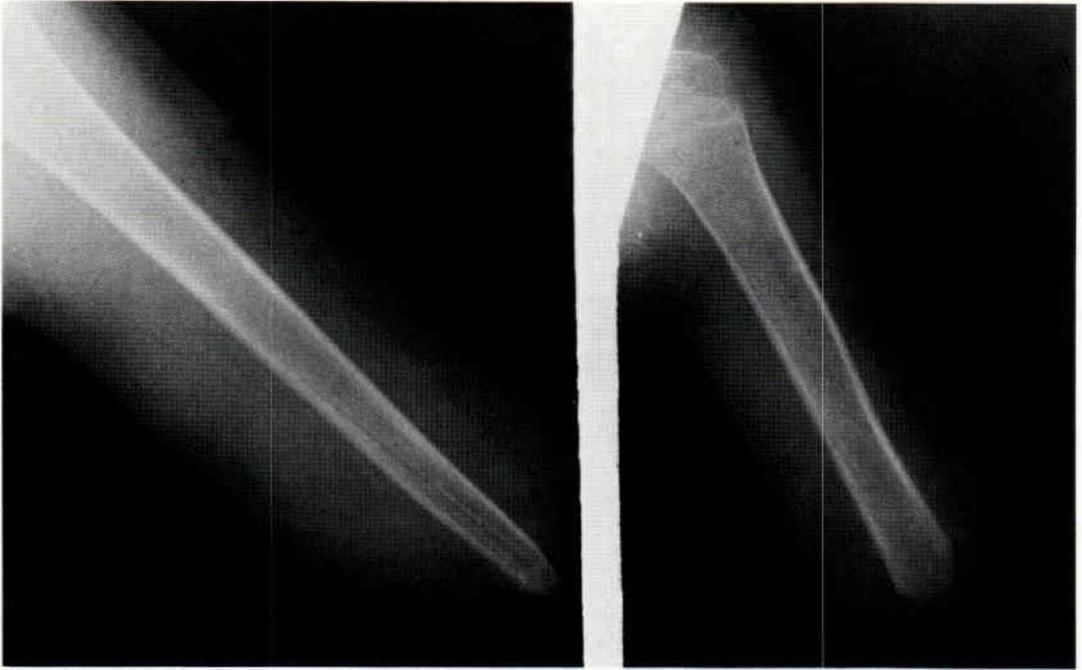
A Pre and Post Operative X-ray of a Humerus.
